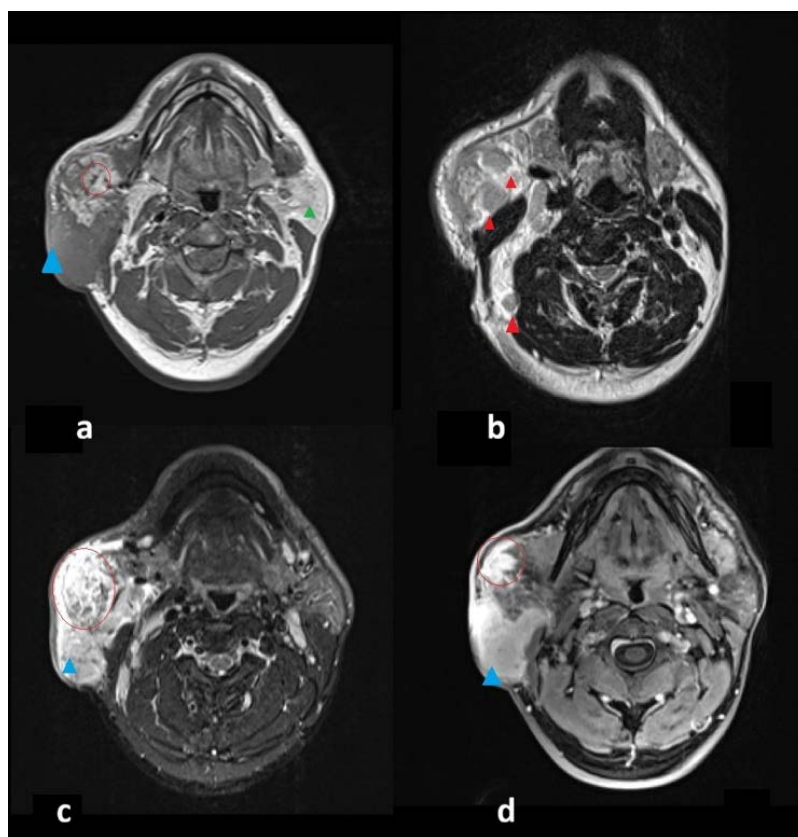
A 47-year-old man with a painless, slowly enlarging mass in the right parotid region. Kimura's disease. Multiparametric MRI of the neck. (a) Axial T1-weighted image demonstrates a subcutaneous periauricular lesion (blue triangle) with slightly increased signal intensity relative to adjacent muscle and poorly defined margins. An intraparotid lymph node (red circle) shows lower signal intensity relative to the surrounding parotid parenchyma (green triangle). (b) Axial T2-weighted image shows a heterogeneous signal intensity, including relatively low T2 signal, associated with intraparotid and lateral cervical lymphadenopathies (red triangles). (c) Axial dynamic contrast-enhanced fat-suppressed T1-weighted gradient-echo image (VIBE) demonstrates early and progressive enhancement of the lesion (blue triangle), without significant washout, consistent with an inflammatory pattern, and showing subtle internal signal voids suggesting vascularity. The intraparotid lymph node (red circle) shows early enhancement. (d) Axial fat-suppressed T1-weighted spin-echo image shows relatively homogeneous enhancement of the lesion (blue triangle). The intraparotid lymph node (red circle) also demonstrates homogeneous enhancement.
